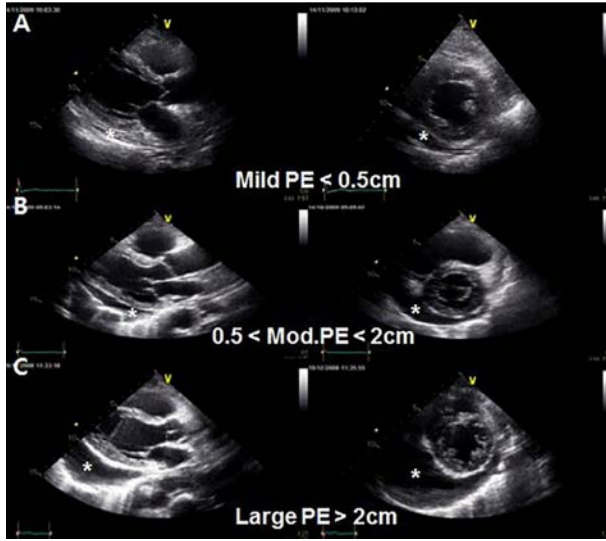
Examples of assessment of severity of pericardial effusion based on the maximum diameter of the effusion on B mode echocardiography. The effusion is identified by the asterisk: (A) small pericardial effusion behind the left ventricle; (B) moderate pericardial effusion; (C) large pericardial effusion in the same location.
